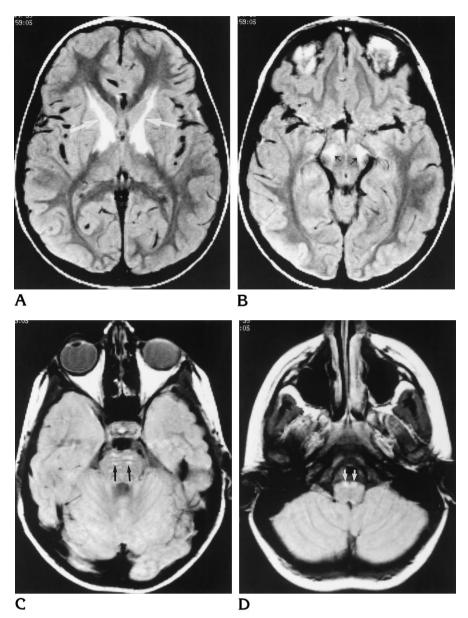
Axial fast spin-echo MR images (2540/19) in a 7-year-old boy with progressive decline in school performance.
